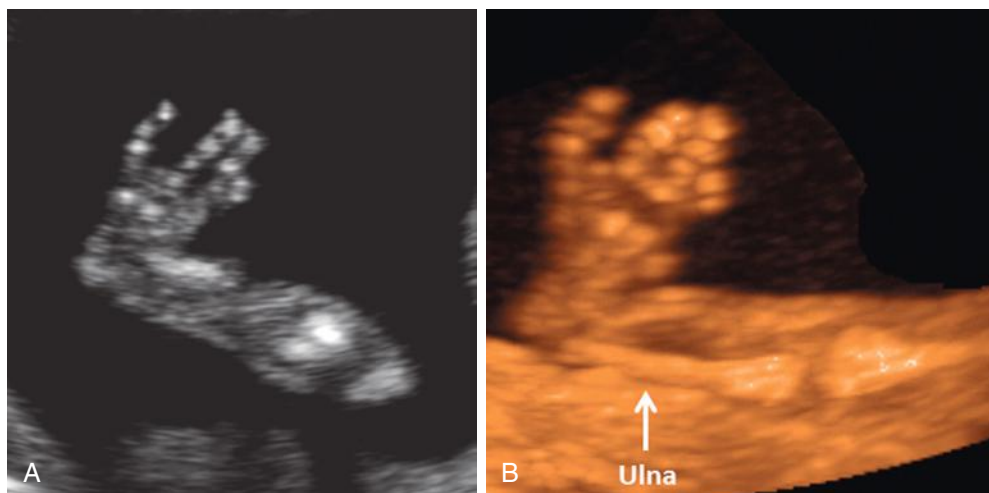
Sonogram of a fetus with radial aplasia using two-dimensional ultrasound (A) and three-dimensional maximum intensity projection mode (B). The hand deviates toward the side of the absent bone (radius).
